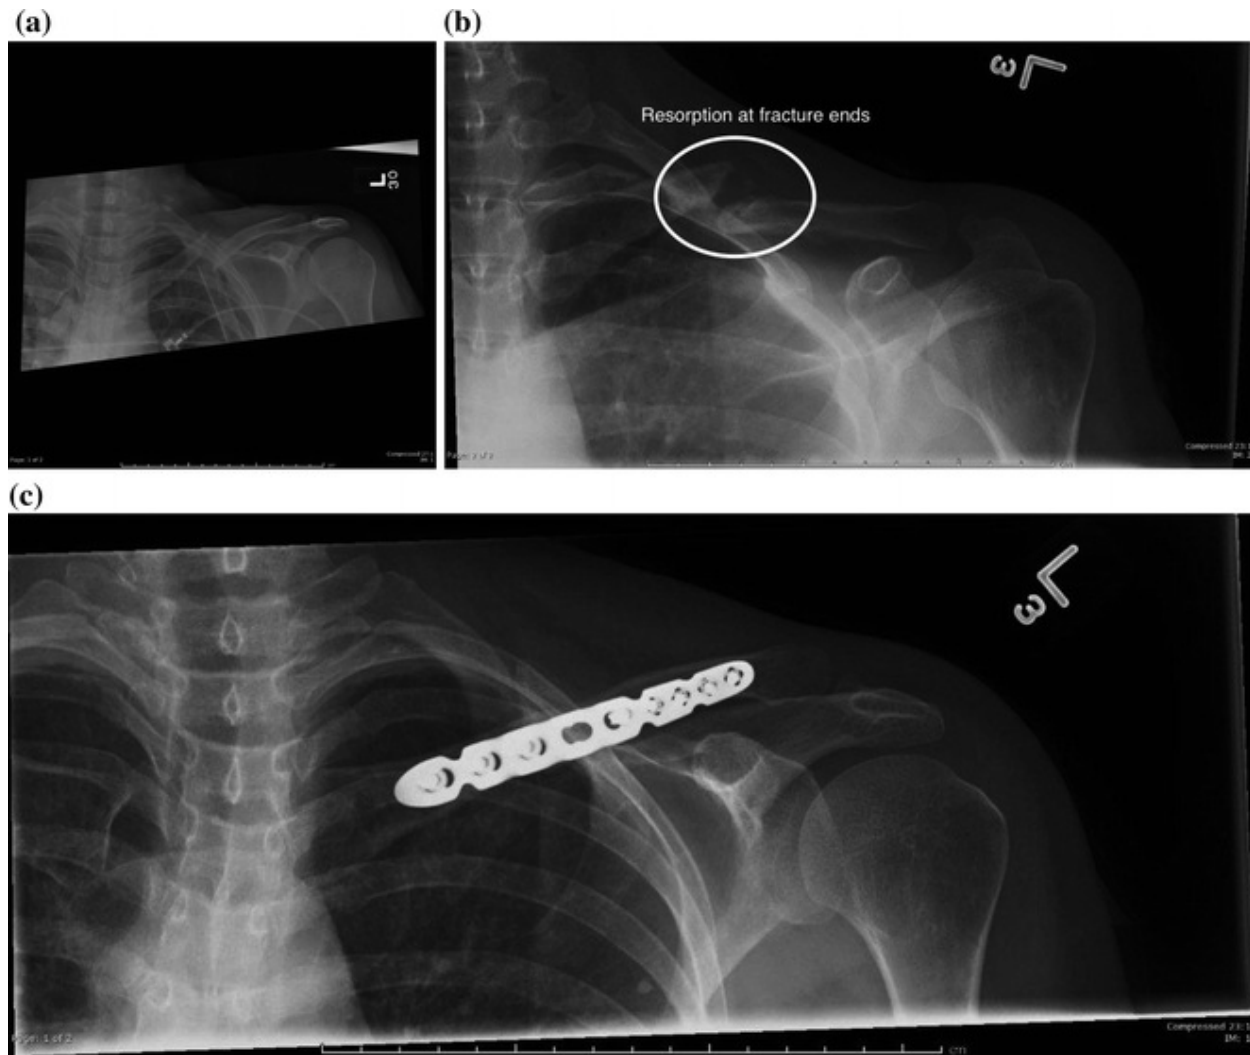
Patient with left clavicle fracture without shortening and minimal elevation initially treated non-operatively. a Injury radiograph. b Nonunion radiograph after 3 months showing resorption and established atrophic nonunion. c Healed clavicle fracture after treatment with open reduction and internal fixation and bone graft
